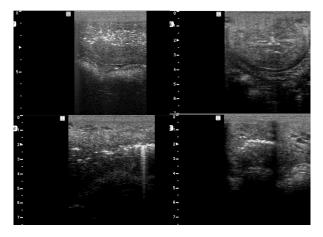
Ultrasonographic appearance of pneumometra in a mare
